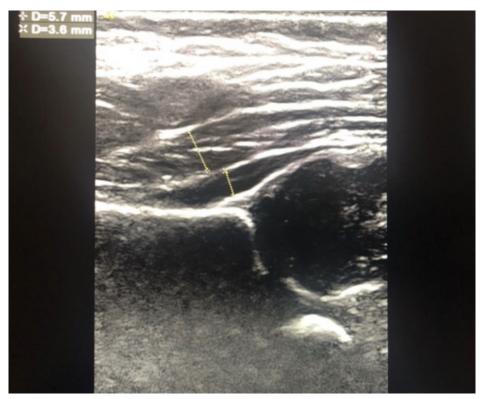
A 37-day age-old girl, Graf method type 1 (mature) hip ultrasound image alpha angle: 67° beta angle: 48° gluteus medius muscle thickness: 5.7 mm gluteus minimus muscle thickness: 3.6 mm
